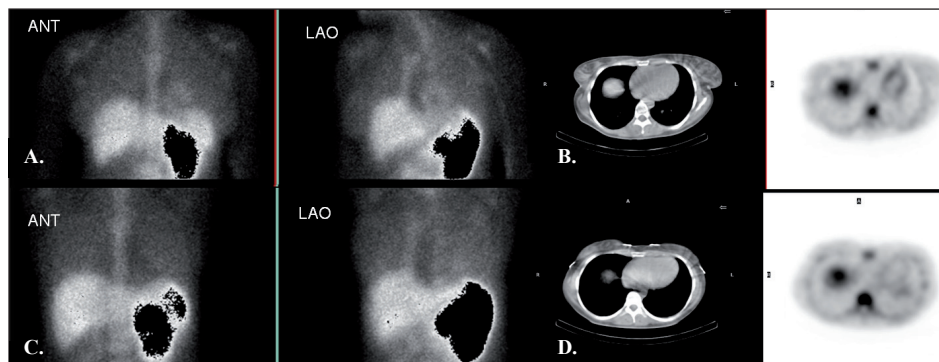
Images of case 3. A. Anterior and left anterior oblique planar views during acute phase demonstrate increased depreotide myocardial uptake. B. Two months later with the patient in remission, obviously reduced uptake is evident in the same views. C. Transverse CT and SPET images during acute phase, and D. Two months later. Myocardium/rib ratio decreased from 1.82 to 1.27.
